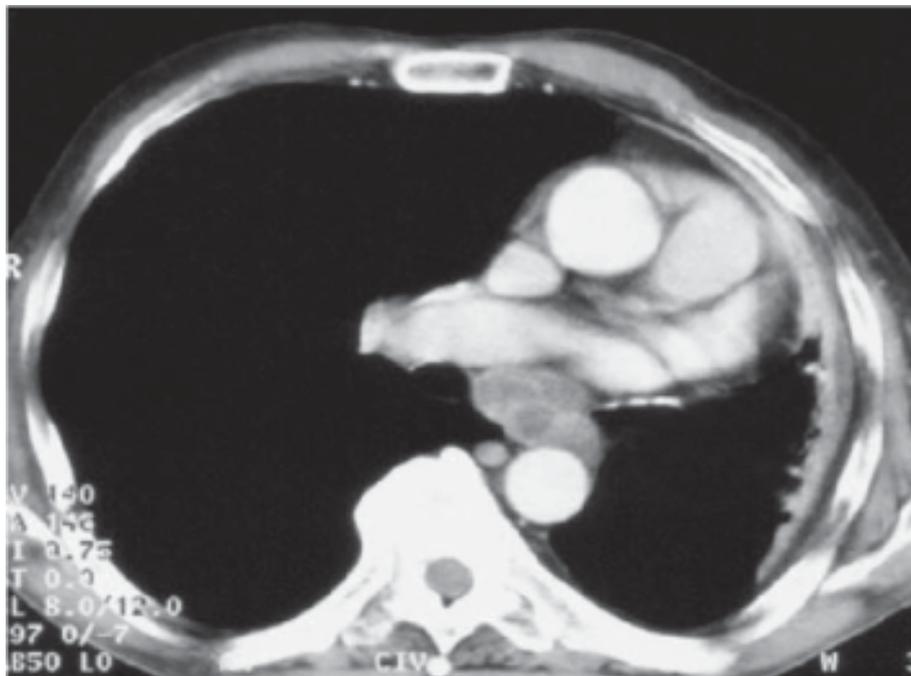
CT scan showing enlarged mediastinal lymph nodes having areas of central low attenuation with peripheral rim enhancement.
